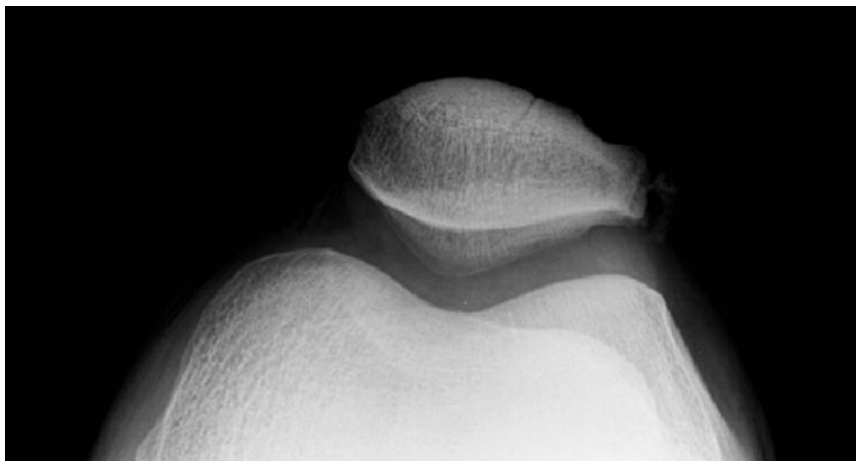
Radiograph at 6-month follow-up shows excision of accessory ossification center.
